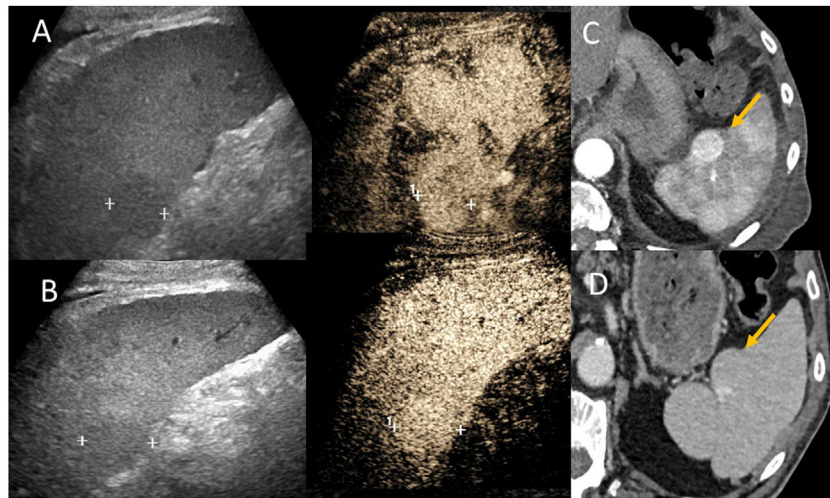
79-year-old male. (A) Baseline ultrasound with incidental finding of a solid focal splenic lesion (between cursors); hypochoic, well-defined, with an appearance not typical of a haemangioma. (A and B) Contrast-enhanced ultrasound in arterial phase at 20 seconds (lesion between cursors) (A) and parenchymal phase at 70 seconds (lesion between cursors). (C and D) Correlation with computed tomography, showing early homogeneous enhancement of the lesion in the arterial phase (yellow arrow) (C) and maintained in the venous phase (yellow arrow) (D). Characteristic enhancement of a benign lesion. The suggested diagnosis was hamartoma.
